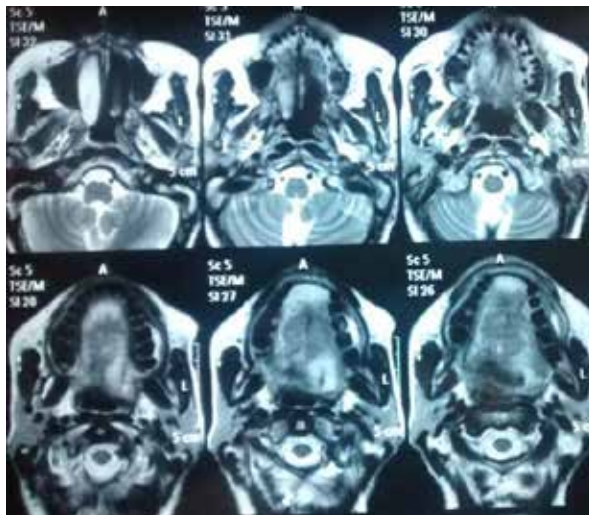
MRI image of the lesion
